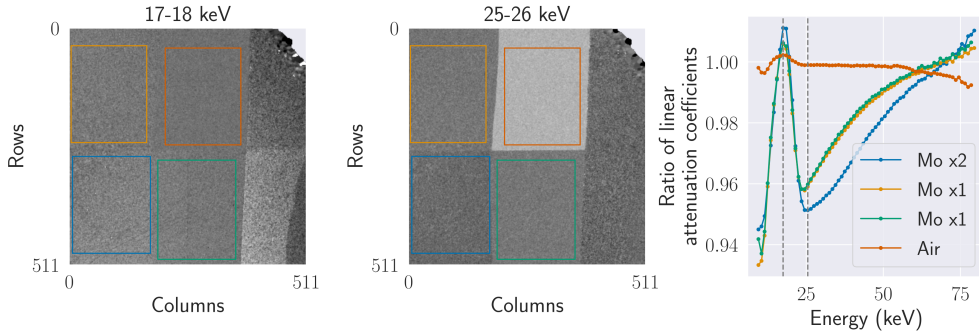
The relative linear attenuation coefficients over energy of Mo foils and air, with the corresponding labelled images at 17.0—18.0 and 25—26 keV as indicated by the vertical dashed lines. The x-ray tube voltage used in this measurement was 90 kVp with a GaAs detector. The coloured squares show the manually selected region of interest where the median of that part of the image over energy was used to generate the line plots.
